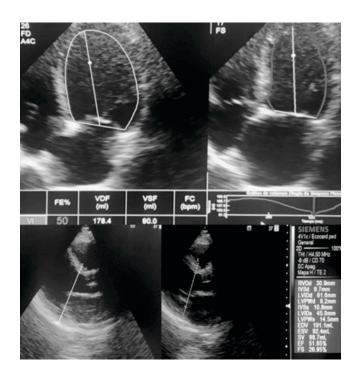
Echocardiogram after the third month of treatment. Shows improvement in LVEF to 50%. even with dilation of the left cavities. Also: E/e′6. PSAP 35mmHg.
